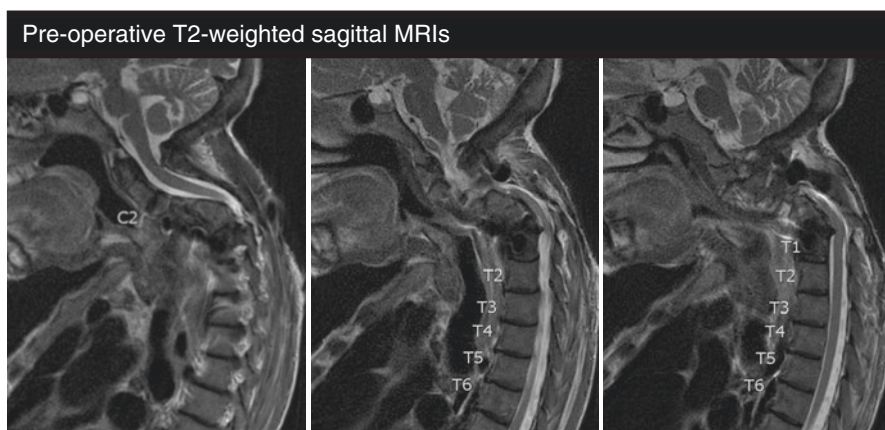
Preoperative T2-weighted sagittal MRIs show kyphotic angulation at the distal junction of the prior C3-C7 posterior spine instrumentation with flattening of the cord at C7-T1 secondary to a dorsal osteophyte and a small dorsal epidural fluid collection
